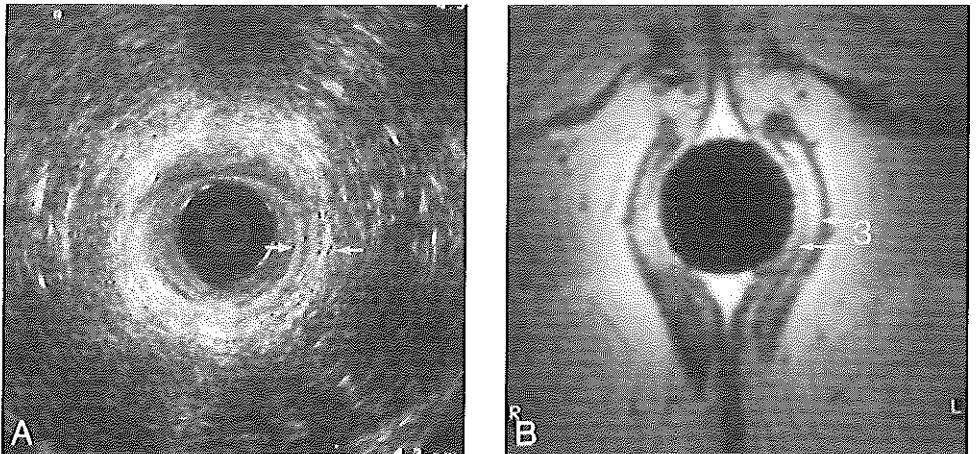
Axial image through the lower part of the external sphincter in a female (level indicated in Fig. 4.6). At this level no internal sphincter is present. The hyperechoic band (between the arrows) is much thicker (A) than the double-layered external sphincter (3), well-delineated with MRI (B).
